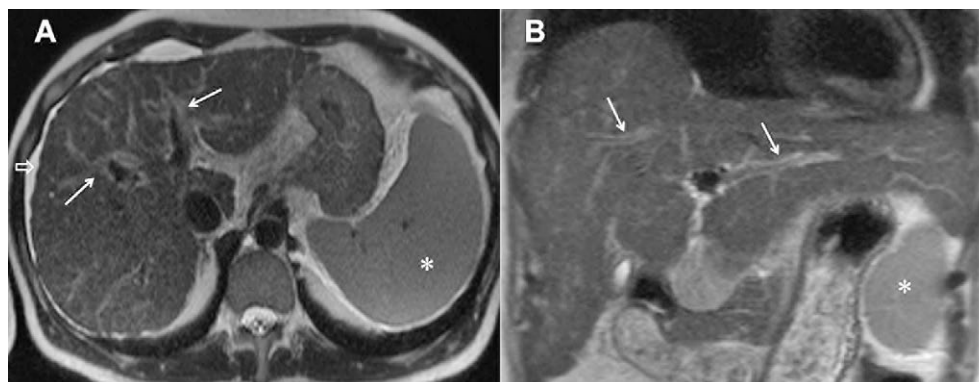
Periportal hyperintensity in primary biliary cirrhosis. Axial T2-weighted image depicts periportal hyperintensity around medium-sized portal triads (arrows) in a 55-year old female patient with micronodular cirrhosis (lace-like fibrosis) (open arrow). Note also splenomegaly (asterisk) and small amount of free fluid around spleen (A). Coronal T2-weighted MR image in another 47-year old PBC patient shows periportal hyperintensity (arrows) and diffuse hepatomegaly as the most common morphological liver change in PBC. Note also the "kissing sign" (asterisk on the spleen)(B).
